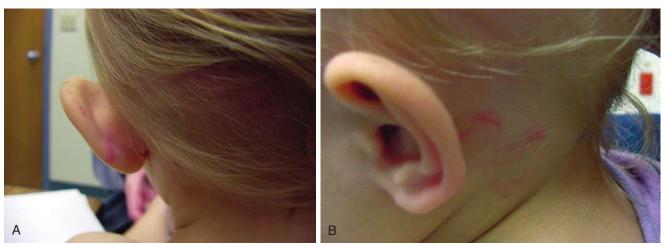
Subgaleal hematomas. This toddler, in the care of mother's paramour, was reportedly well until about 45 minutes after being put to bed, when she "woke up screaming." On being picked up, she was noted to have a "mushy head." At the hospital, she was found to have large bilateral subgaleal hematomas, with surface bruising and petechiae over the occipitoparietal scalp. She also had semicircular bruises behind her left ear consistent with fingernail marks. Skull radiographs and a head CT scan showed no evidence of skull fracture or intracranial injury. Further examination revealed extensive bruising and lacerations of the introitus consistent with sexual assault (see Fig. 6-92 *B*). The perpetrator apparently grabbed her by her hair and by her head, leaving fingernail marks while in the process of assaulting her. Her hair was pulled so forcibly that the scalp was pulled away from the skull, leading to the extensive subgaleal bleeding, which continued to expand over the ensuing 72 hours. A, Thinning of the hair from hair loss behind her left ear are fingernail are evident, and the subgaleal hematoma over her left temporal area is so large that it is pushing her external ear out laterally. B, Curvilinear marks behind her left ear are fingernail impressions.
